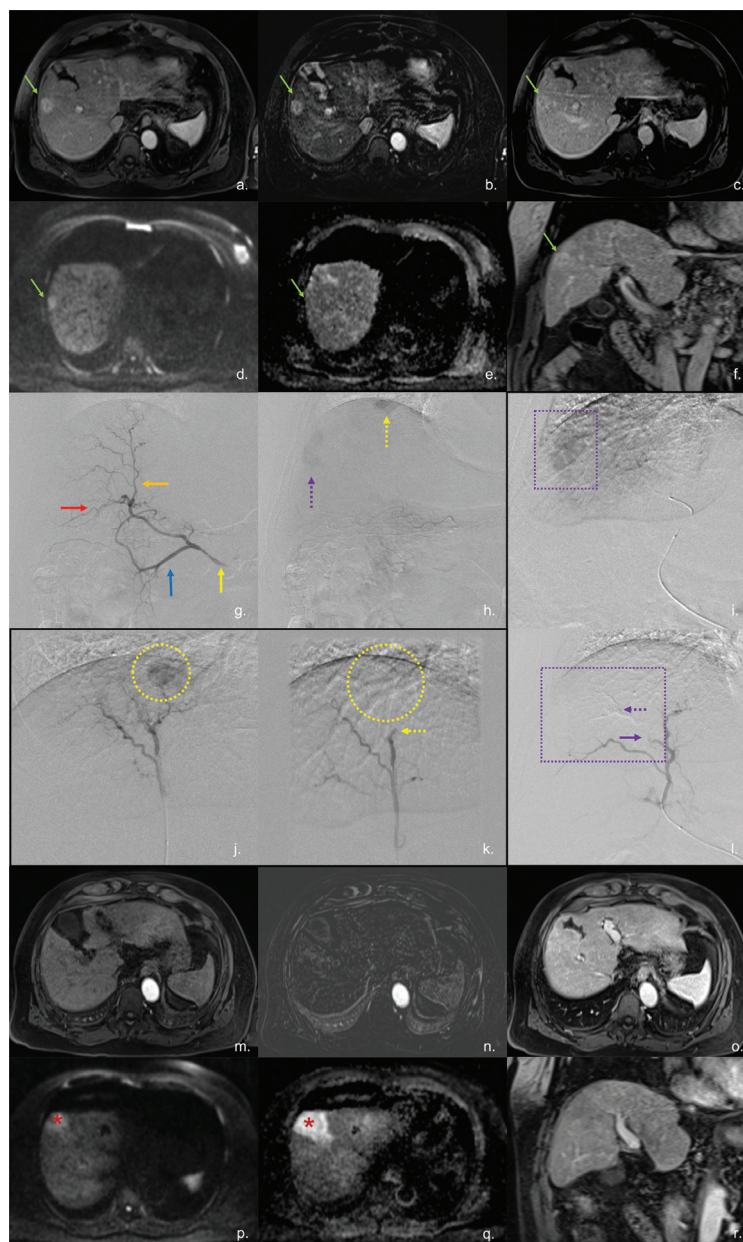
A 58-year-old patient with cryptogenic cirrhosis and multifocal hepatocarcinoma, Child–Pugh A–5 points, ECOG 0, BCLC B; receive treatment for cirrhosis but not sorafenib. (a–f) MRI where HCC is depicted in segment VIII which has early arterial enhancement (a, b), central wash out (c, f), and restriction to diffusion (d and e, where d is b800 and e is the ADC map). (g–l) Pictures from arteriography of DEB-TACE therapy. (g) Normal arterial irrigation to right hepatic lobe; continuous yellow arrow: right hepatic artery, continuous blue arrow: right lateral hepatic artery, continuous orange arrow: ventral right paramedian artery, continuous red arrow: dorsal right paramedian artery. (h) Discontinuous purple arrow points out the lesion located in VII segment and discontinuous yellow arrow: marks out the lesion located subdiaphragmatic in the interline between VII and VIII segments. (j, k) Selective arterial microcatheterization of the subdiaphragmatic lesion vascular territory; yellow dotted circle encloses the lesion (j) and the place where the lesion is not visualized after embolization (k) with its respective stagnant artery pointed out by yellow discontinuous arrow. (i, l) Selective arterial microcatheterization of the VIII segment lesion vascular territory; purple dotted square demarcates the lesion (i) and the place where lesion is not visualized after embolization (l) and its respective stagnant artery pointed out by purple continuous arrow and also the embolization material with purple continuous arrow. (m–r) MRI 10 months after DEB-TACE: treated lesions are not visible; so, mRECIST was complete response; red asterisks point out gallbladder. (a, m: T1 + gadolinium in early arterial; b, n: subtraction. c, o: T1 + gadolinium in portal phase. d, p: diffusion–b800. e–q: ADC maps. f–r: coronal T1 + gadolinium in portal phase).
